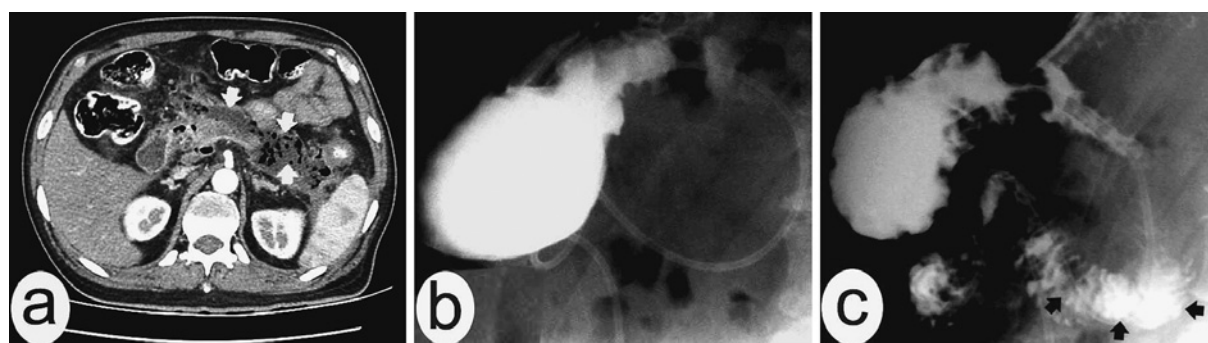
Diagnostic findings of this patient. Contrast-enhanced computed tomography revealed effusions and bubbles (white arrows) around an edematous pancreas (a); gastrointestinal radiography before mirtazapine treatment revealed little passage of contrast agent into the lumen of duodenum 10 minutes after intake (b); gastrointestinal radiography after mirtazapine treatment revealed emptying of an appreciable amount of contrast agent into the lumen of duodenum (black arrows) 3 minutes after intake (c).
